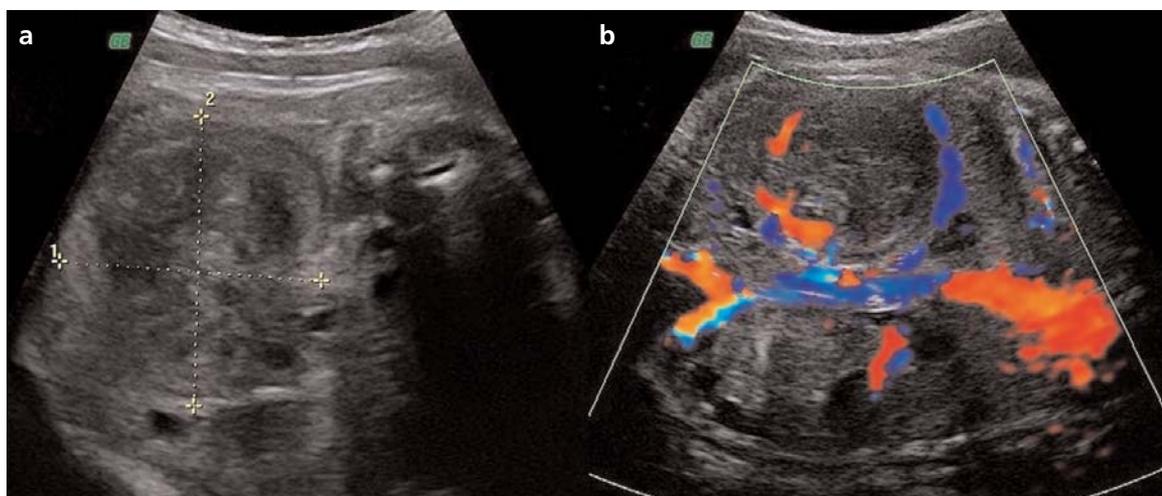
Axial image of the tumoral mass appearing at the right renal fossa of the fetus (a) and the ring view of the highly vascular mass at the color Doppler sonography (b).
